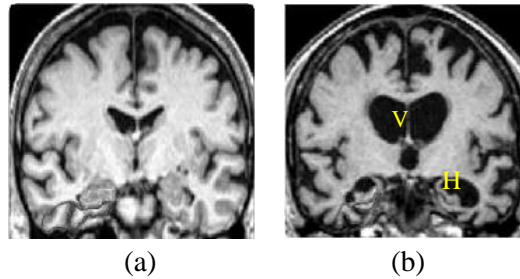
MRI (a) Cognitive Normal Brain (b) Atrophied Brain
